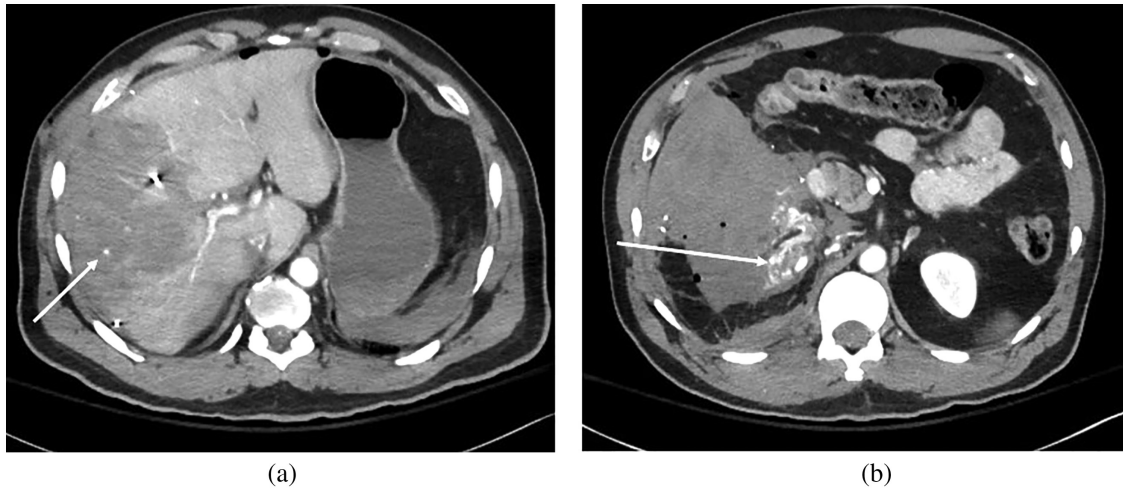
CT images showing (a) a grade 4 right hepatic lobe injury and (b) a grade 5 injury to the right kidney with active hemorrhage, and a right colon injury at the hepatic flexure. The arrows point to areas of active arterial hemorrhage.
